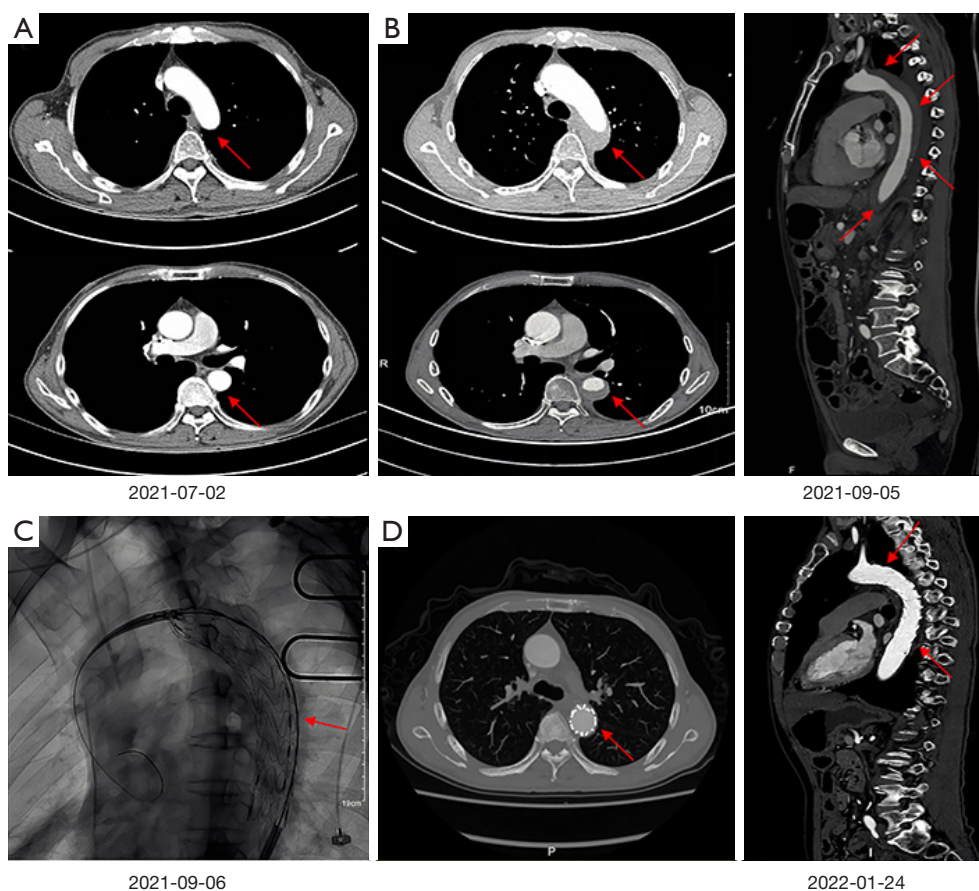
Chest CT before and after fruquintinib treatment. (A) Aortic dissection and aortic aneurysm were not observed in CT scan at baseline. (B) Descending TAD with intramural hematoma occurred 6 weeks after fruquintinib treatment. (C) Stent-graft implanted into the aorta. (D) Reexamination after aortic dissection stent implantation. The red arrows indicate the lesion. CT, computed tomography; TAD, thoracic aortic dissection.
